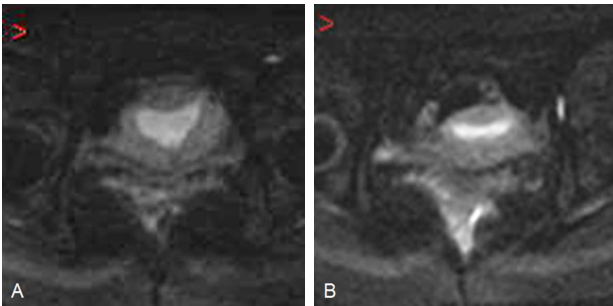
Axial DWI in a 31-year-old woman with normal endometrium in secretory phase (A) and in proliferative phase (B), the ADC value were $1.25 \times 10^{-3} \text{mm}^2/\text{s}$ and $1.11 \times 10^{-3} \text{mm}^2/\text{s}$ respectively.
